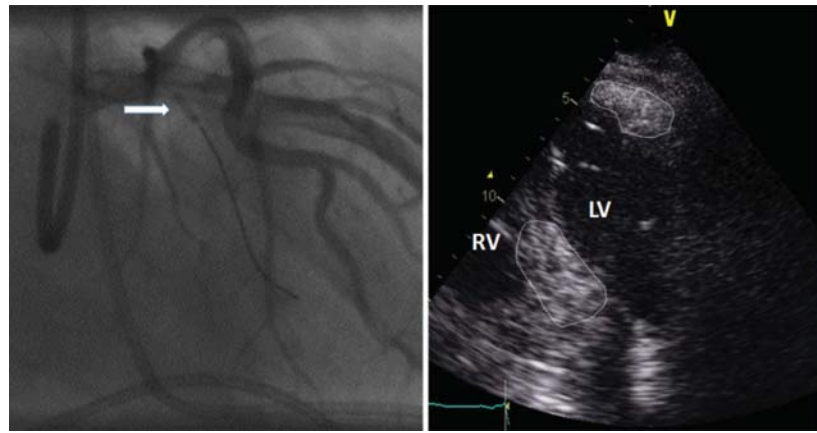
Change of strategy after misplacement of contrast in the patient of (Figs. 1 and 2). The most proximal septal branch (arrow, hardly noticeable in coronary angiography of Fig. 1) is wired and an over-the-wire balloon is inserted and inflated at its proximal part (left). After contrast injection (right) a modified apical 4-chamber view shows opacification of the basal septum but at the same time the apical lateral wall is also demarcated (right). LV: left ventricle, RV: right ventricle.
